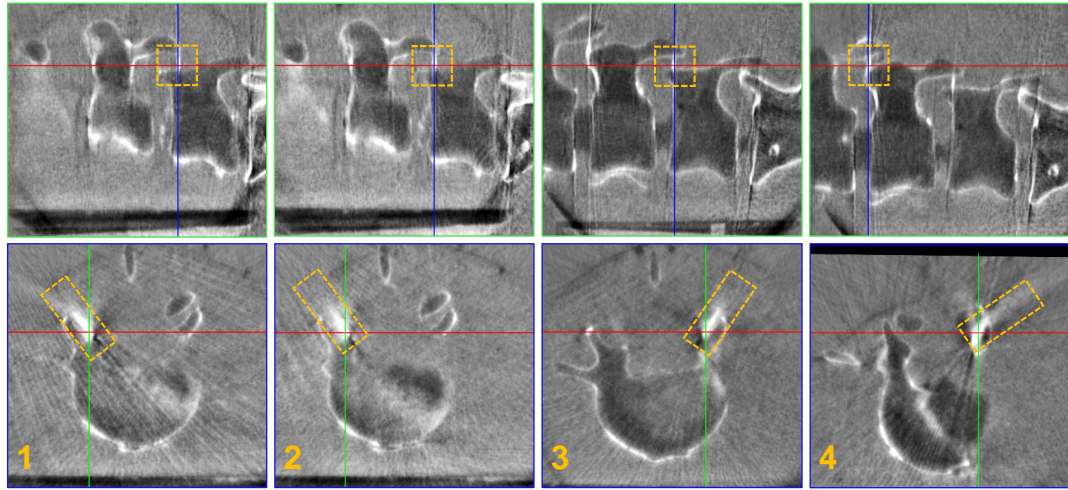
Sagittal (*top*) and axial (*bottom*) slices of the verification cone-beam CT images after needle insertion, showing successful targeting of the facet joint in all cases (*yellow boxes*). Reprint from [249] with permission of Springer.
